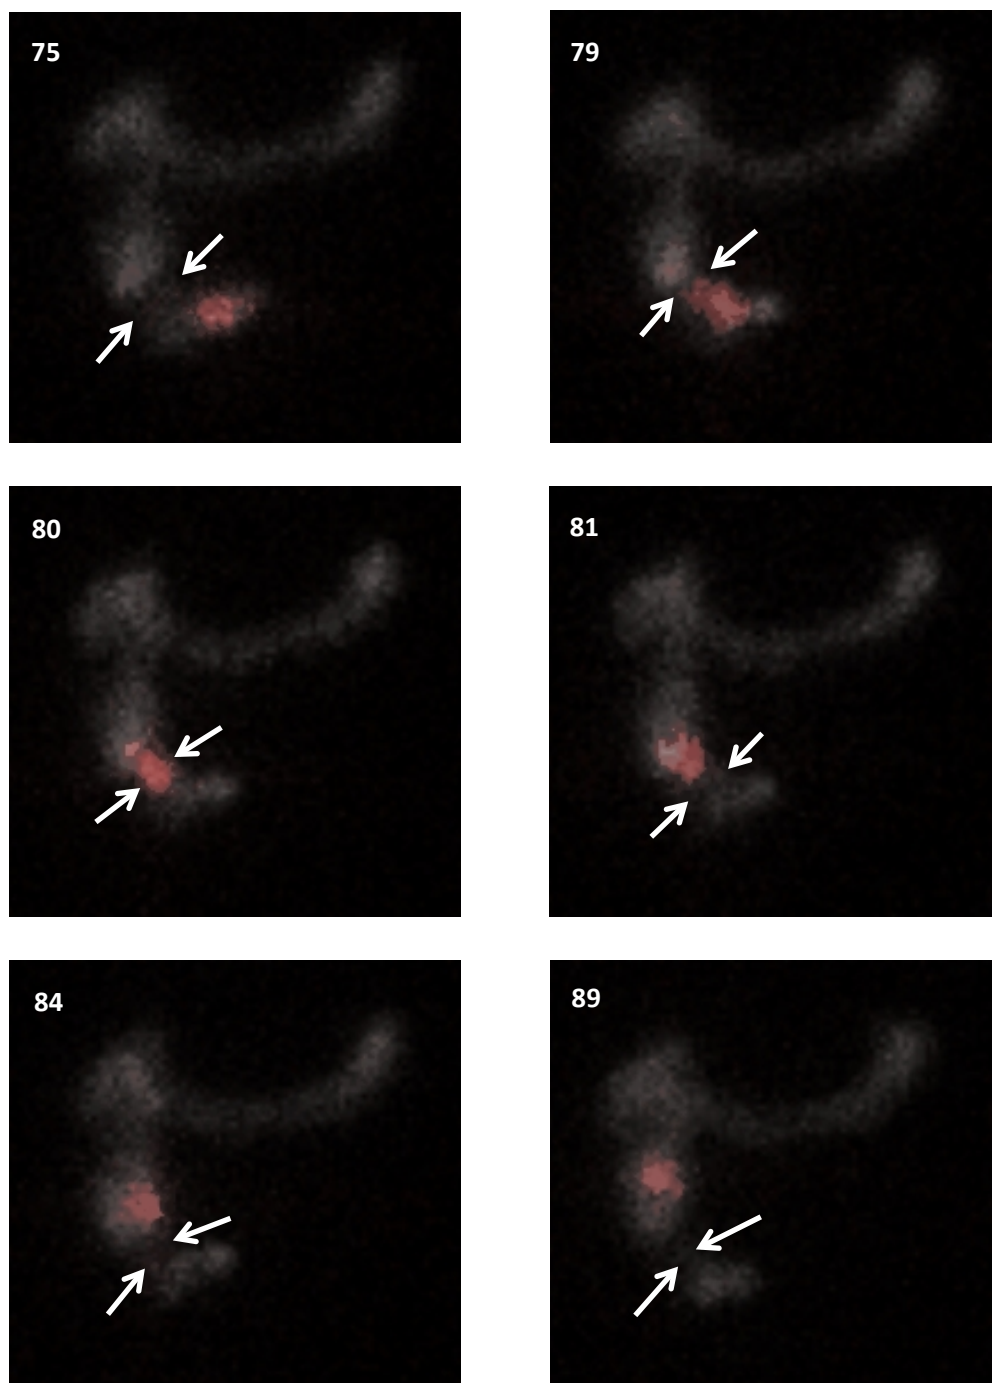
Raw images of dual scintigraphy. Position of the $^{51}\text{Cr}[\text{EDTA}]$ labelled WMC, relative to the background ^{111}In [diethylenetriamine penta-acetic acid] ($^{111}\text{In}[\text{DTPA}]$) was determined frame-by-frame (each frame represents an acquisition time of 60 s; frame number shown top left). In this series of images, the WMC (reddish spot) can be seen to pass from the terminal ileum (frames 75 and 79), through the ICJ (frame 80), into the caecum (frames 81 and 84), and eventually into the ascending colon (frame 89). Position of the ICJ is evident in all frames (between white arrows).
